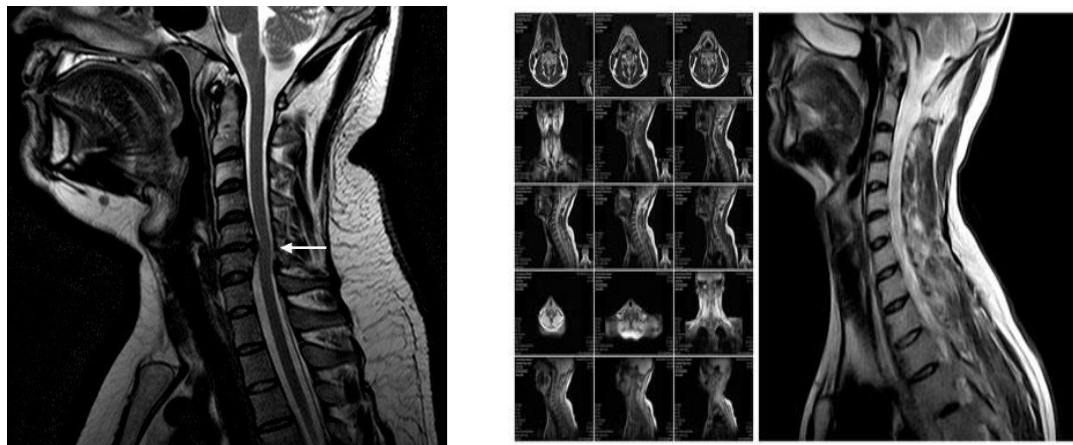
Figure # 1.2 A 52-year-old female presented with a 3-month history of right arm pain, numbness, tingling, and weakness, particularly in the biceps and triceps. The pain worsened with neck movement. On examination, she had diminished sensation in the right C6 dermatome, mild muscle weakness, and a positive Spurling's test. Cervical spine radiographs showed mild degenerative changes at C5-C6. MRI revealed a right-sided disc herniation at C5-C6, compressing the right C6 nerve root, confirmed on both T2 and T1-weighted images. The patient was initially treated conservatively with NSAIDs, cervical traction, and physical therapy. After 6 weeks of limited improvement, she underwent a cervical epidural steroid injection, which provided partial symptom relief. [30]
